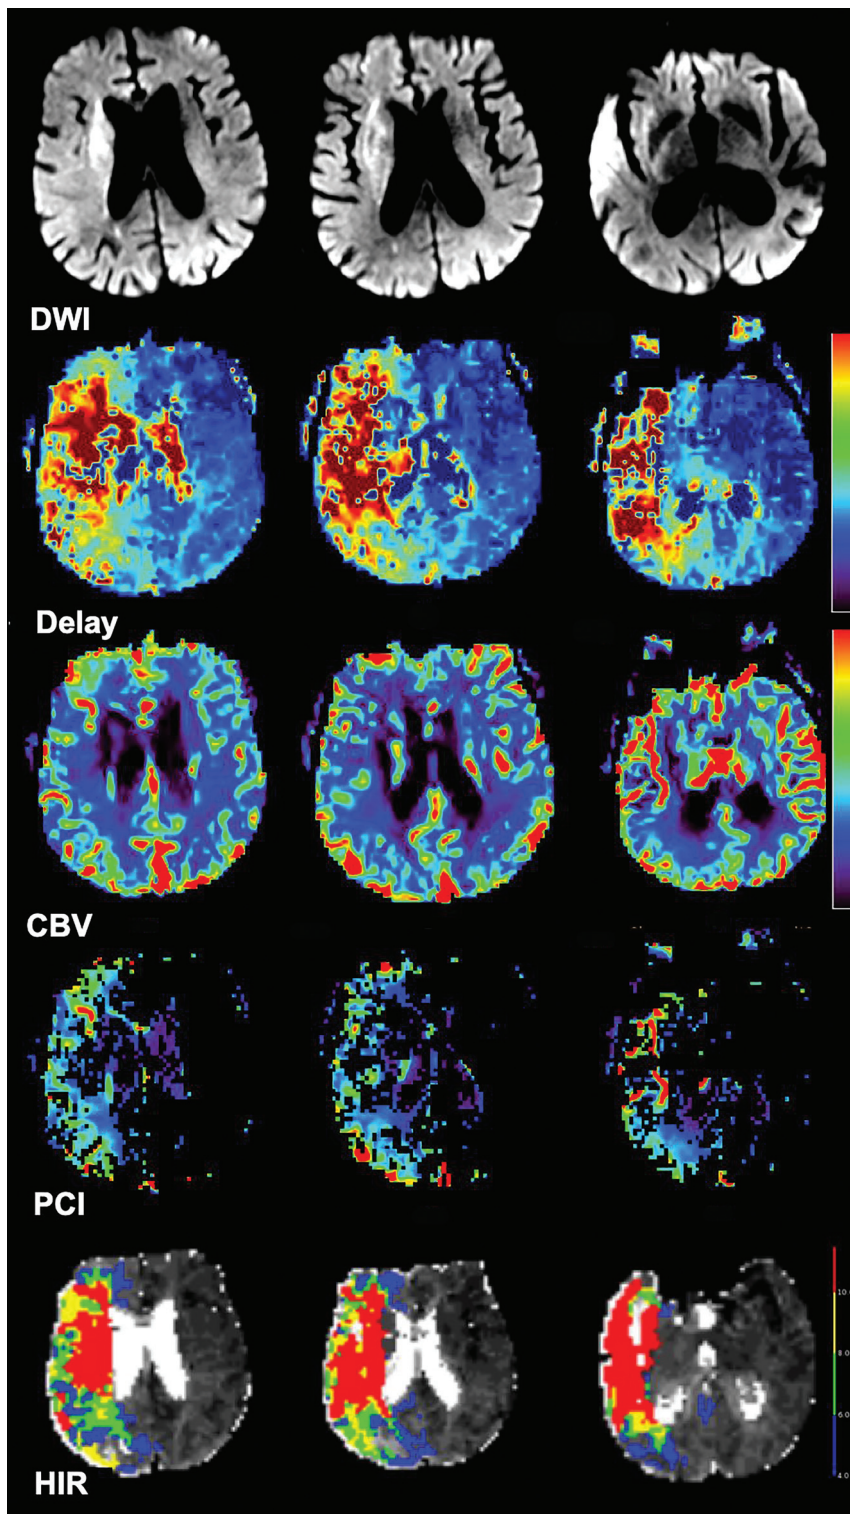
Example of discordance between the PCI and HIR in a patient with sufficient angiographic collaterals. Adult patient with left hemiparesis who underwent MR imaging approximately 4.5 hours after symptom onset. The patient has a right carotid terminus occlusion (not shown). Aligned axial DWI, delay, CBV, PCI, and HIR maps from MR perfusion are shown. There is an ischemic core involving the right basal ganglia, insula, and right temporal lobe. The PCI value is estimated at 130, suggestive of sufficient collaterals. The estimated HIR is 0.49, suggestive of poor collaterals. Baseline catheter angiography (not shown) revealed good collaterals (ASITN 3).
